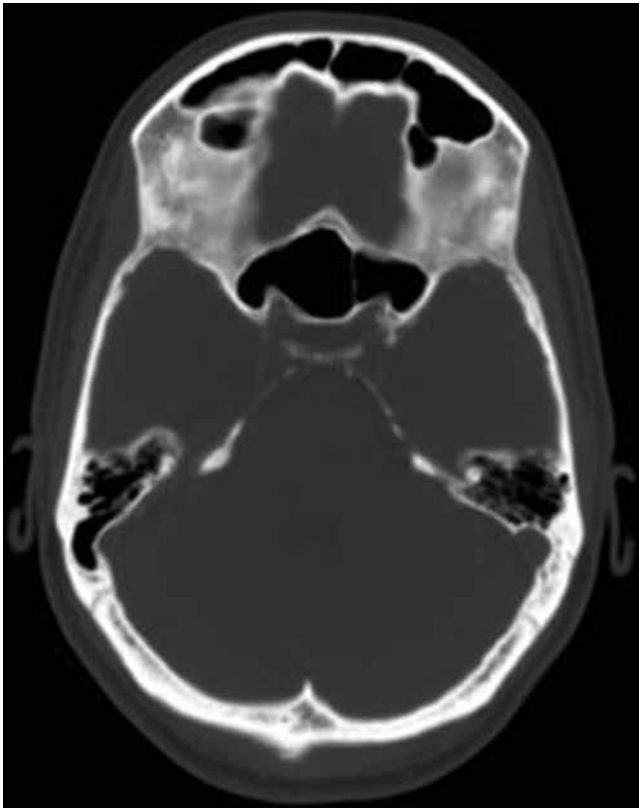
Case 1. Axial bone window CT scan showing enlargement of the sphenoid sinus with normal bone thickness.
